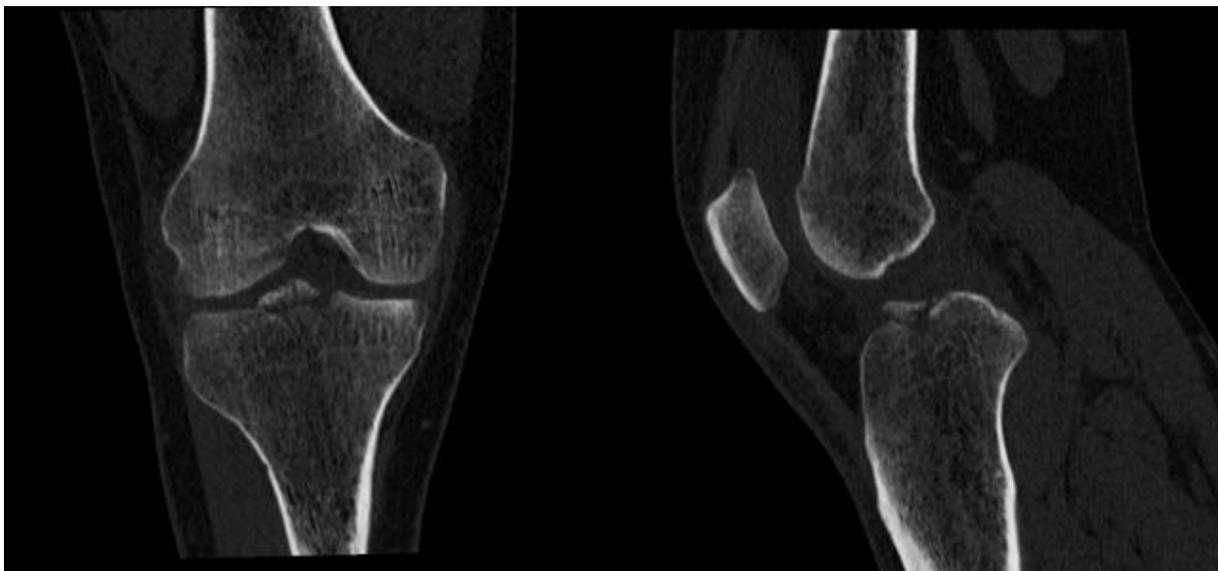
Preoperative X-ray of the one of our patients.
